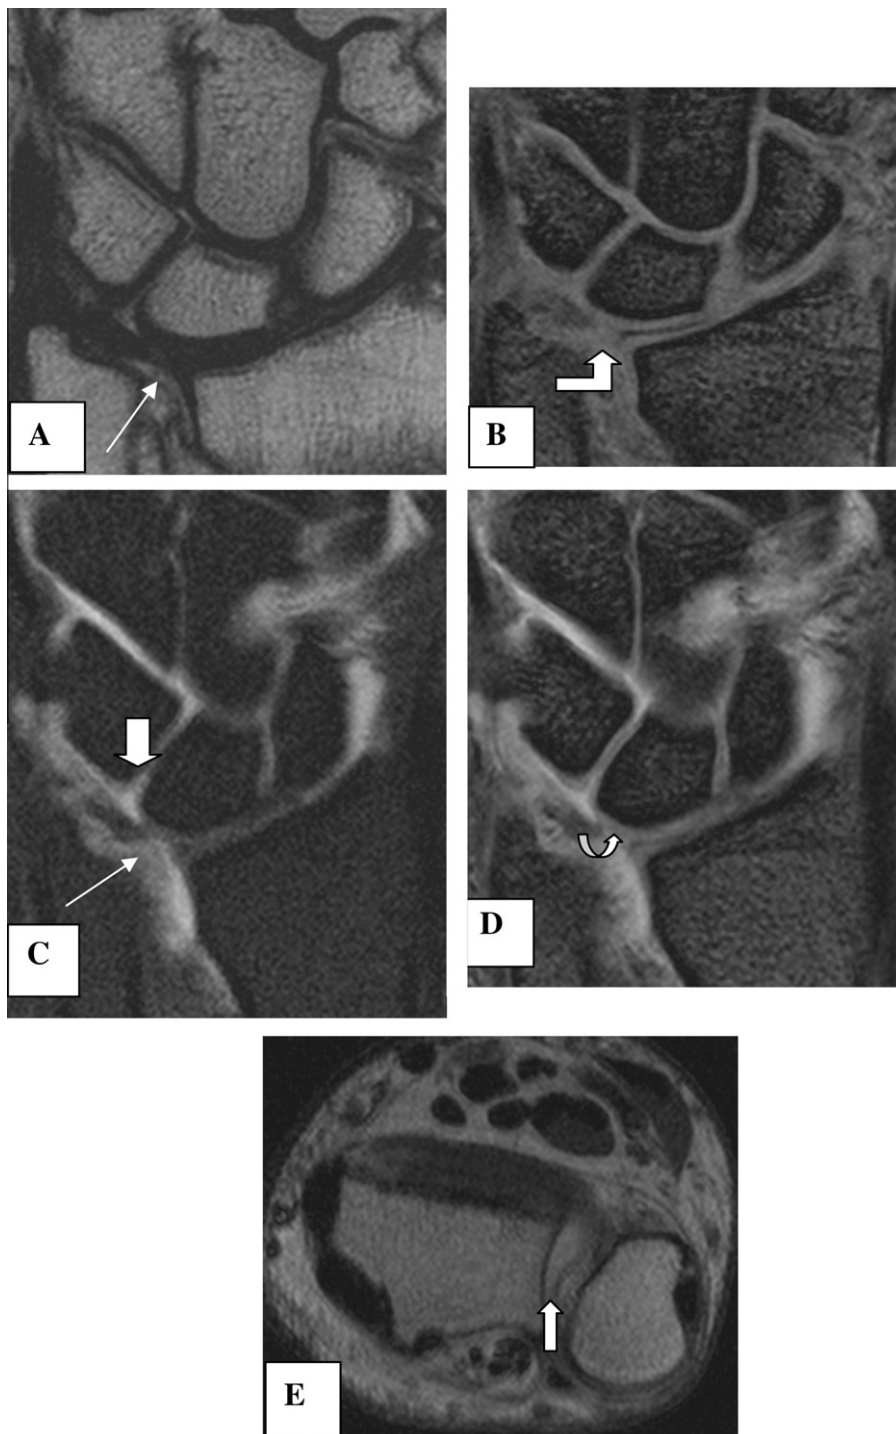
Male patient complaining of chronic ulnar sided right wrist pain, with no history of trauma underwent conventional MRI. Coronal T2 & T2 3D FFE (A & B) revealed a central area of attenuation with altered signal within the TFC (arrow). Evidence of subluxation of the DRUJ is also noted. Intra articular injection into the mid carpal compartment was performed, with leakage into the radio carpal compartment through the luno-triquetral interval, also leakage was observed into the DRUJ, MRA was then done. Coronal fat suppressed T1 WI (C) & T1 3D FFE (D) MR arthrographic images revealed: a large central defect within the TFC class II-C (straight & curved arrows), with leakage of the injected contrast into the DRUJ, delineating the tear. Also a linear bright contrast signal is seen traversing the LT ligament (small arrow), denoting underlying tear. Axial T1 MR Arthrographic image (E) shows subluxation of the DRUJ, with dorsal subluxation of the ulnar head.
